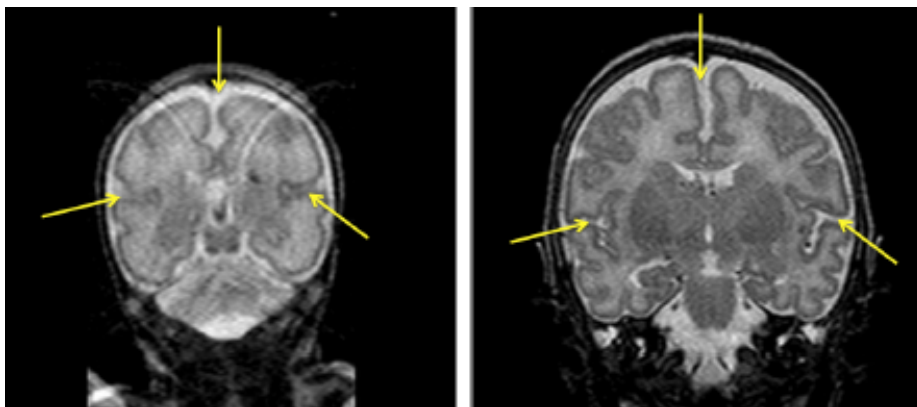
MRI scan for the same extreme premature subject at two different time points. The subject in the image was born at 28 weeks gestational age, first scanned 10 days after birth (29.2 weeks postconceptional age) (left) and then re-scanned with the same protocol one month and a half later (39.85 weeks post-conceptional age) (right). Yellow arrows point to landmarks that are already identifiable at 28 weeks of gestation and remain stable along lifespan. As we can see in the image, the gyrification pattern at term is similar to the adult case (though showing less deep sulci) whereas prior to 40 weeks of GA only few of the sulci are present.
